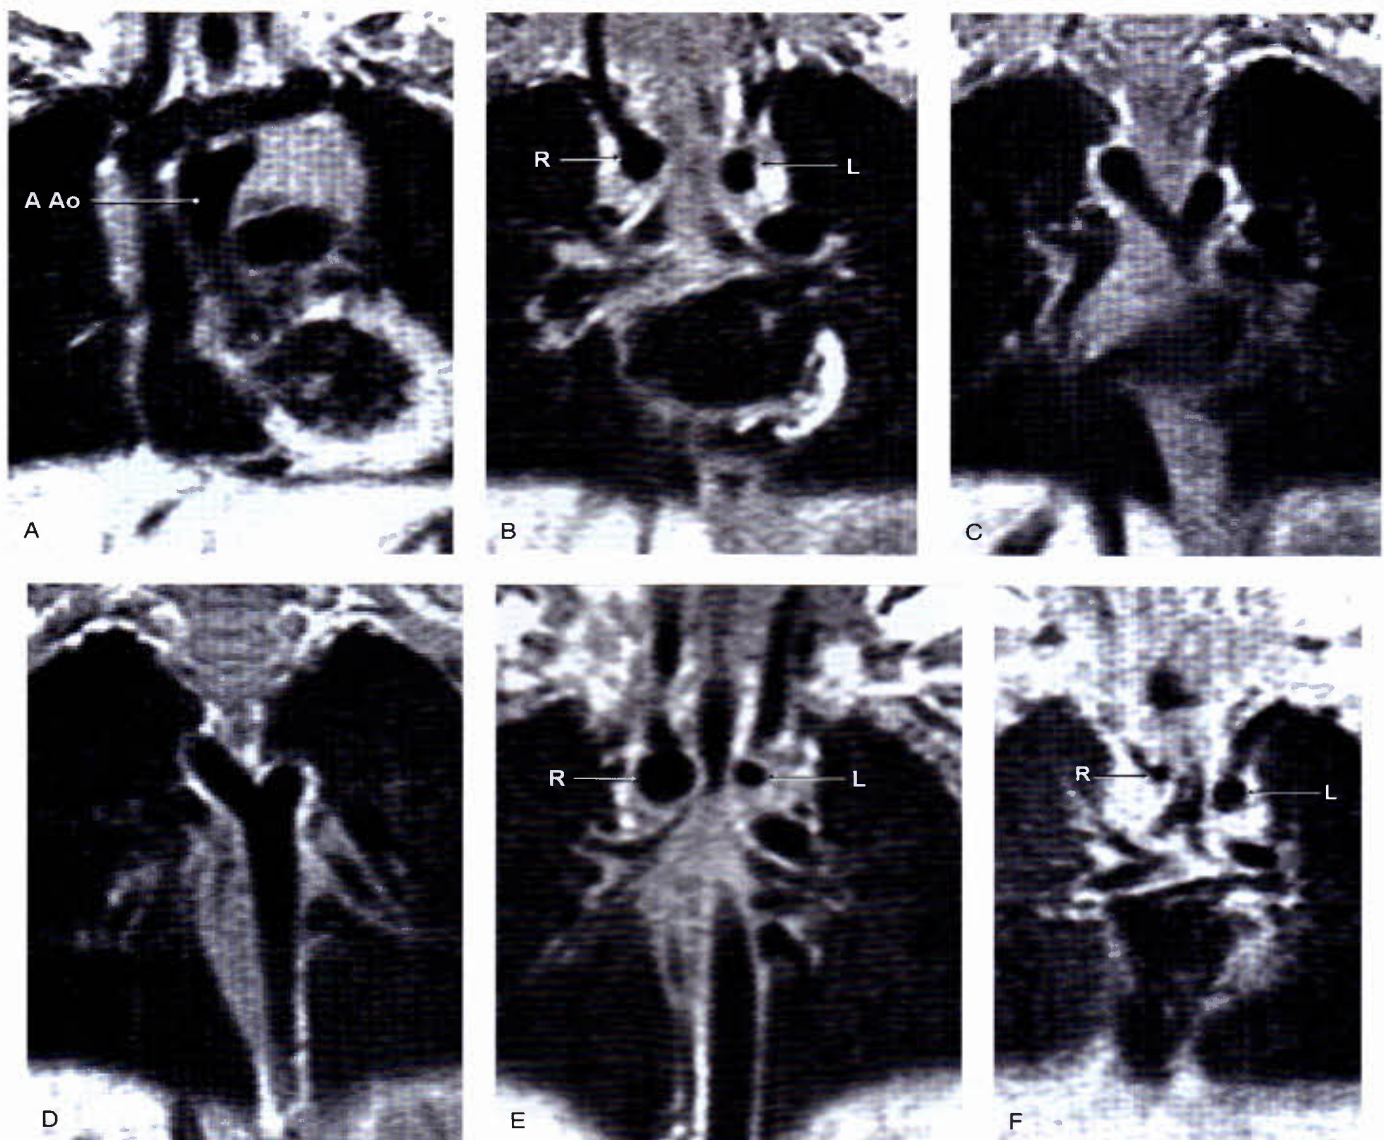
Double aortic arch, both patent. A–D: Spin echo MRI (coronal cuts, anterior to posterior) showing ascending aorta (A Ao) dividing into equal-sized right (R) and left (L) aortic arches reuniting posteriorly as the descending aorta. Coronal images of patients having double arch with (E) dominant right and (F) rare case of dominant left.
